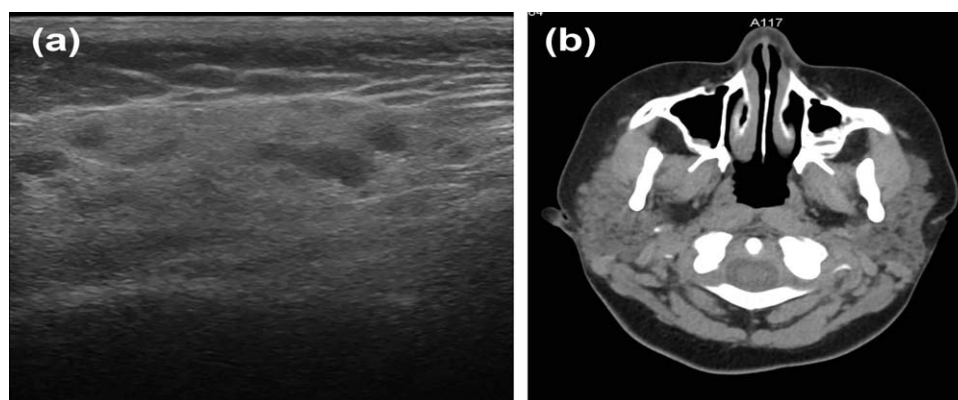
Scattered hypodensities within a uniform enlarged salivary gland on ultrasound (A) and noncontrast computed tomography (B) are consistent with the diagnosis of juvenile recurrent parotitis.
